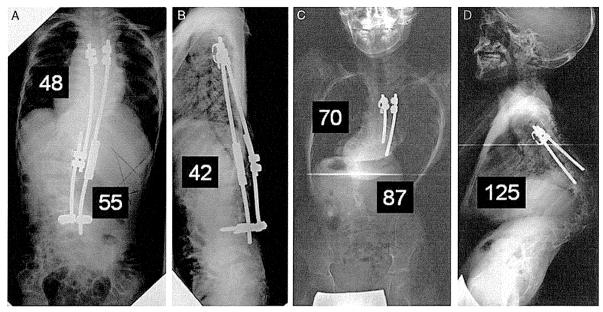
Postoperative radiographs of Patient 2. Growing rod treatment was started at the age of 4 years and 10 months (A, B). Postoperatively, the curves were corrected to 49 and 57 degrees (A). Kyphosis at the thoracolumbar area was corrected to 42 degrees (B). The distal anchors were finally removed due to deep wound infection at 22 months after the first operation. At present, 5 years after the first surgery, the Cobb angle of the main curve is 87 degrees (C) and the kyphosis is 125 degrees (D).
